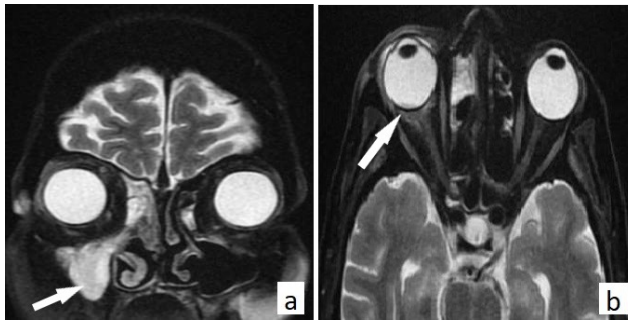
a: MRI brain with contrast- coronal T2w image showing mucosal thickening in right maxillary, ethmoid and frontal sinus; b- Axial T2 fat suppressed image showing mild inflammatory thickening of retrobulbar portion of right optic nerve with thickening of posterior globe layer, irregular enhancing soft tissue phlegmon in retro orbital region in keeping with Infectious optic neuritis and endophthalmitis. Polypoidal mucosal thickening of maxillary, ethmoid, sphenoid s/o fungal sinusitis
